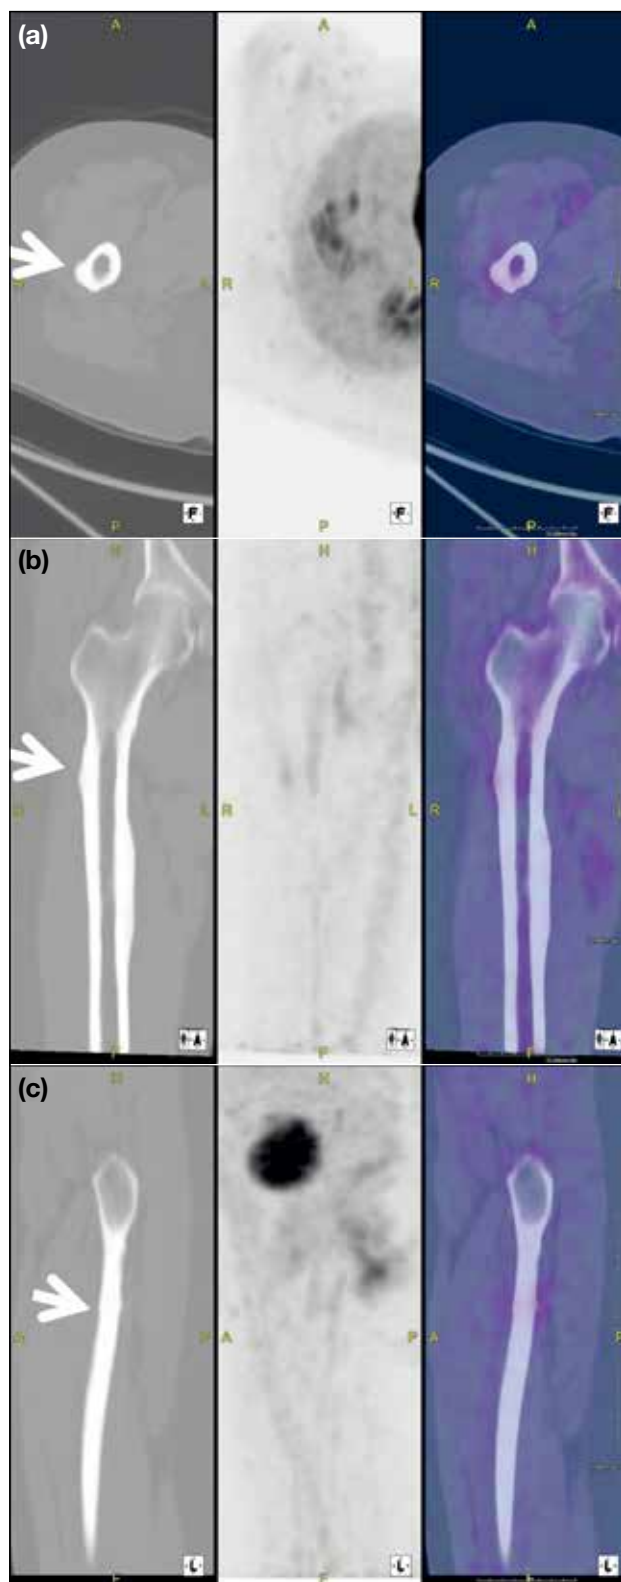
Same patient. Positron emission tomography-computed tomography images taken 3 months before fracture. Multiplanar reformation (a) axial and (b) coronal views showing subtrochanteric lateral cortical beaking (arrows) corresponding to the fracture shown in Figure 4c.
